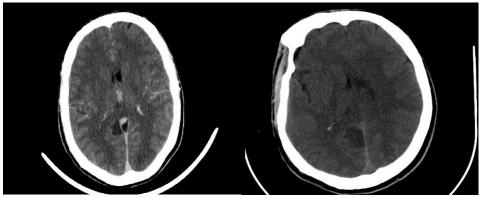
Brain CT scan without and with IV contrast demonstrated some ill-defined hypodense occupying lesions that were partially contrast-enhanced.
